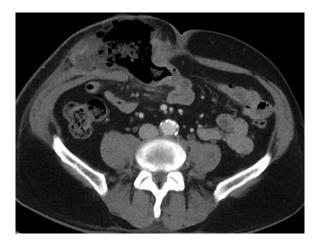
A patient with ileal conduit presented 1 year postoperatively with severe abdominal pain and clinically unwell. CT showed a necrotic loop of small bowel which had herniated through the site of the ileal conduit which was confirmed at surgery.
